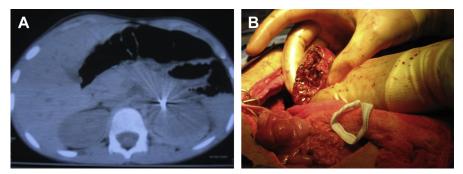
Gunshot wound to the abdomen. An 8-year-old with a gunshot wound to the flank. Owing to an unclear trajectory and hemodynamic stability of the child, a computed tomography (CT) scan was undertaken, demonstrating tract of bullet into the left kidney with active extravasation of contrast. At laparotomy, an isolated renal injury was demonstrated and treated with partial nephrectomy. (*A*) CT demonstrating tract of projectile into left kidney. (*B*) Operative image demonstrating a well-perfused kidney with a laceration amenable to partial nephrectomy.
